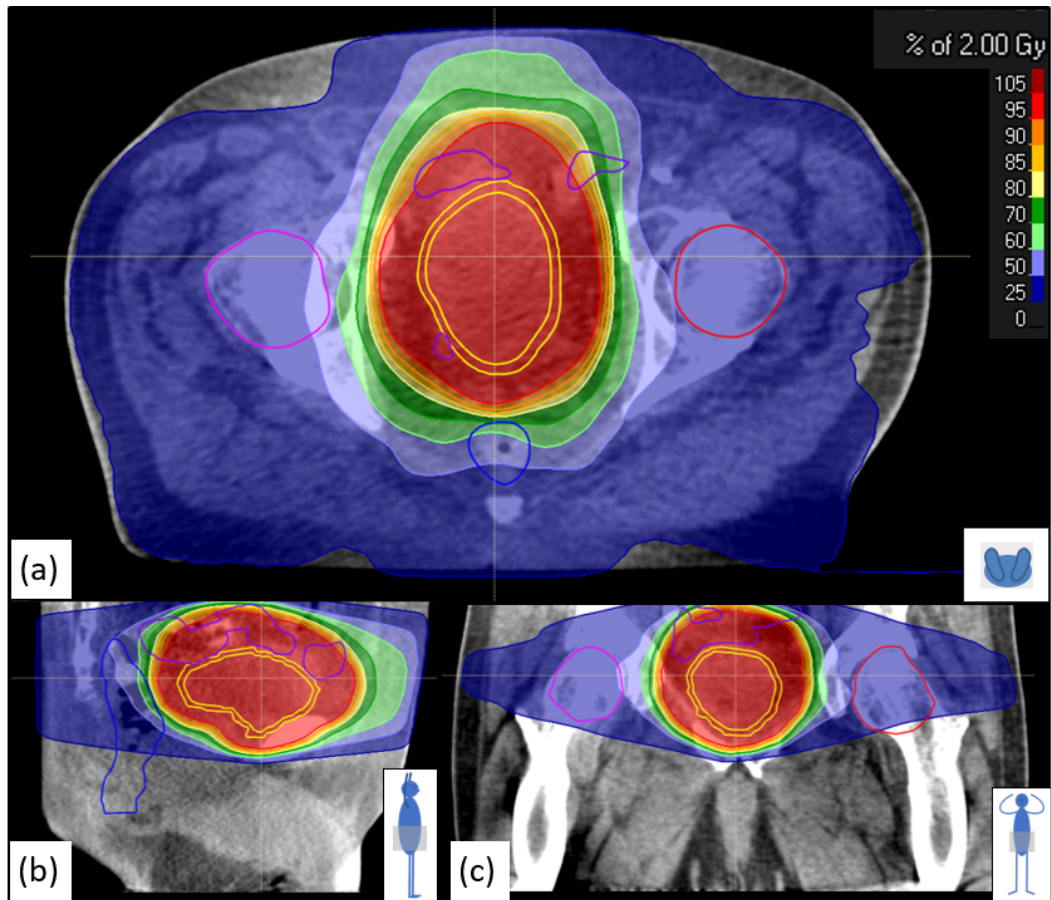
Re-calculated dose distribution on the CBCT for a single (2 Gy) fraction using the standard 64 Gy plan. Images show (a) transaxial, (b) sagittal and (c) coronal views.
